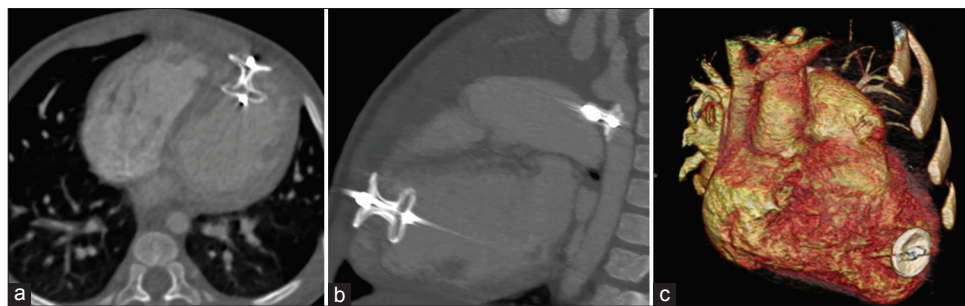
(a) Axial section of CT showing obliteration of the interventricular septum and RV apex; (b) Sagittal plane showing both the mVSD device and duct occluder; (c) Volume-rendered image demonstrating an RV disk on the free wall
